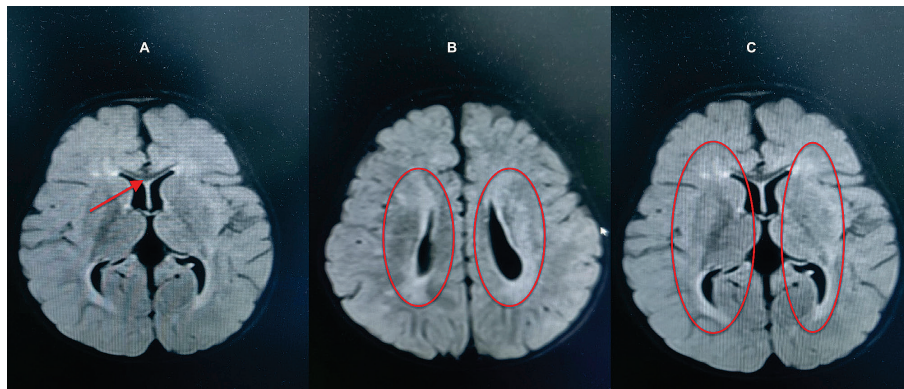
Axial view of brain magnetic resonance imaging
